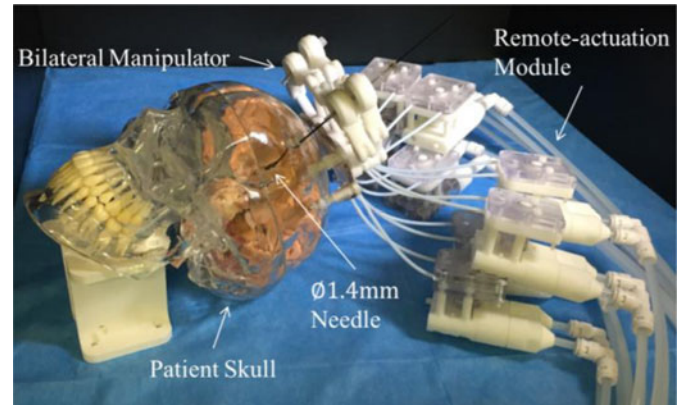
Slave module of the proposed MR safe robot for intra-op MRI-guided bilateral stereotactic procedures.
